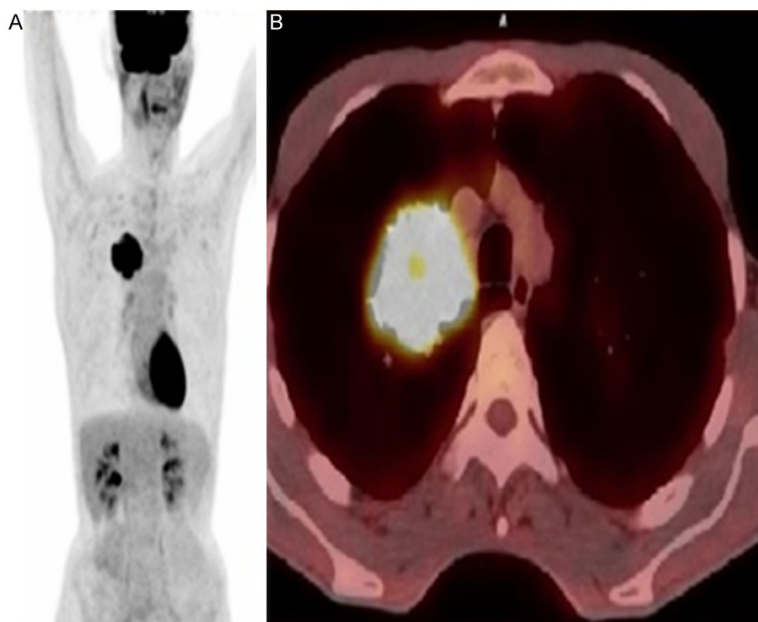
PET/CT images of 52 years old male with adenocancer on right lung. SUVmax; 14.8 A. MIP images of PET C. Fusion PET/CT.
